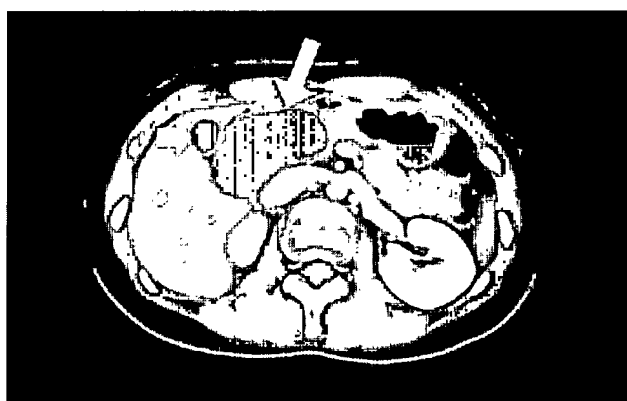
Abdominal CT scan showed dilated common bile duct (long arrow) and a compressed gallbladder (short arrow)
